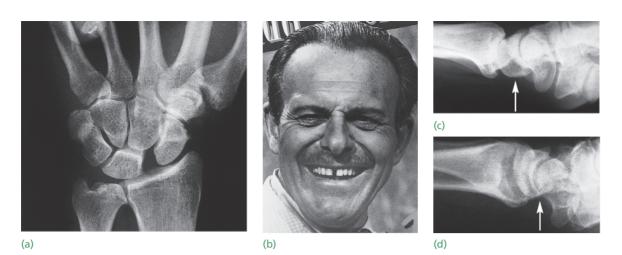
Carpal instability (a) A year after 'straining' his wrist this patient was still complaining of pain; the X-ray shows a gap between the scaphoid and the lunate (the Terry-Thomas sign) and rotation of the scaphoid. (b) The actor Terry Thomas with the trademark gap between his front teeth (reproduced by permission; © United Artists Inc.) (c) In the lateral view the lunate is tilted dorsally and the scaphoid ventrally (DISI); compare this with (d), an example of VISI, showing volar tilt of the lunate.
